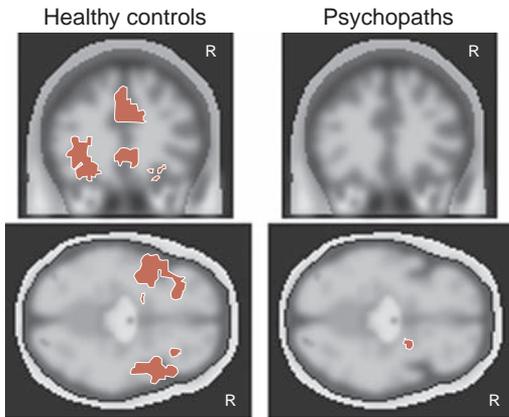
● Healthy controls show a robust fear response in anticipation of an adverse stimulus. Psychopaths fail to develop a similar fear. (Adapted from Birbaumer N, Veit R, Lotze M, et al. Deficient fear conditioning in psychopathy: a functional magnetic resonance imaging study. *Arch Gen Psychiatry*. 2005;62(7):799-805.)
